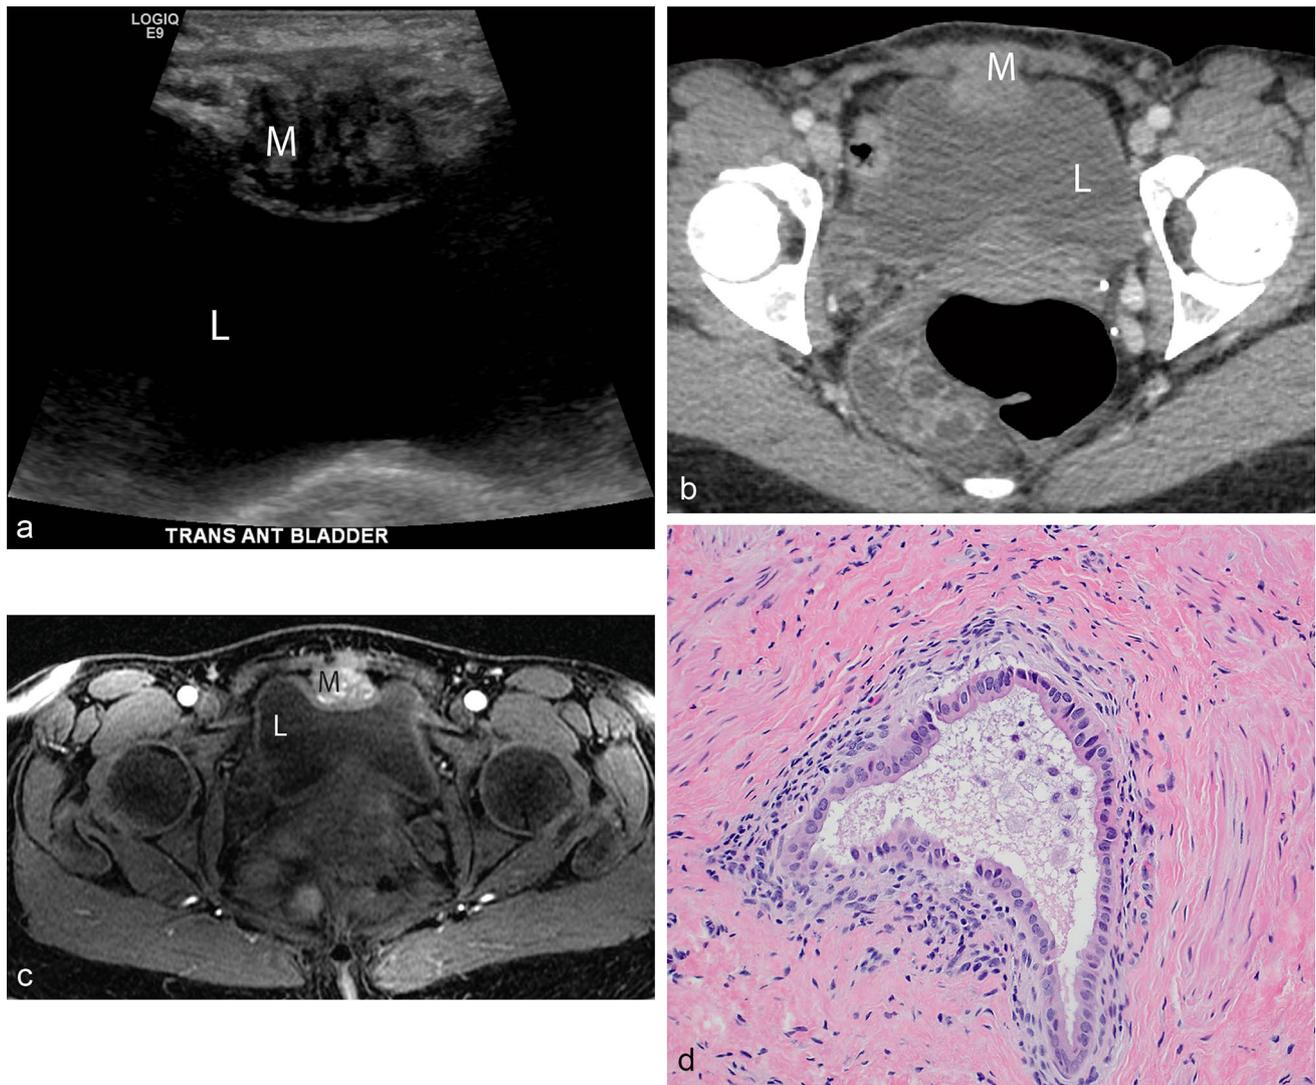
46-year-old female with an endometriosis implant in the bladder wall. a Transverse grayscale ultrasound shows a rounded heterogeneously hypoechoic mass indenting the anterior bladder wall. b Axial contrast-enhanced CT and c axial contrast-enhanced T1W MR of the bladder similarly show a heterogeneous enhancing mass along
